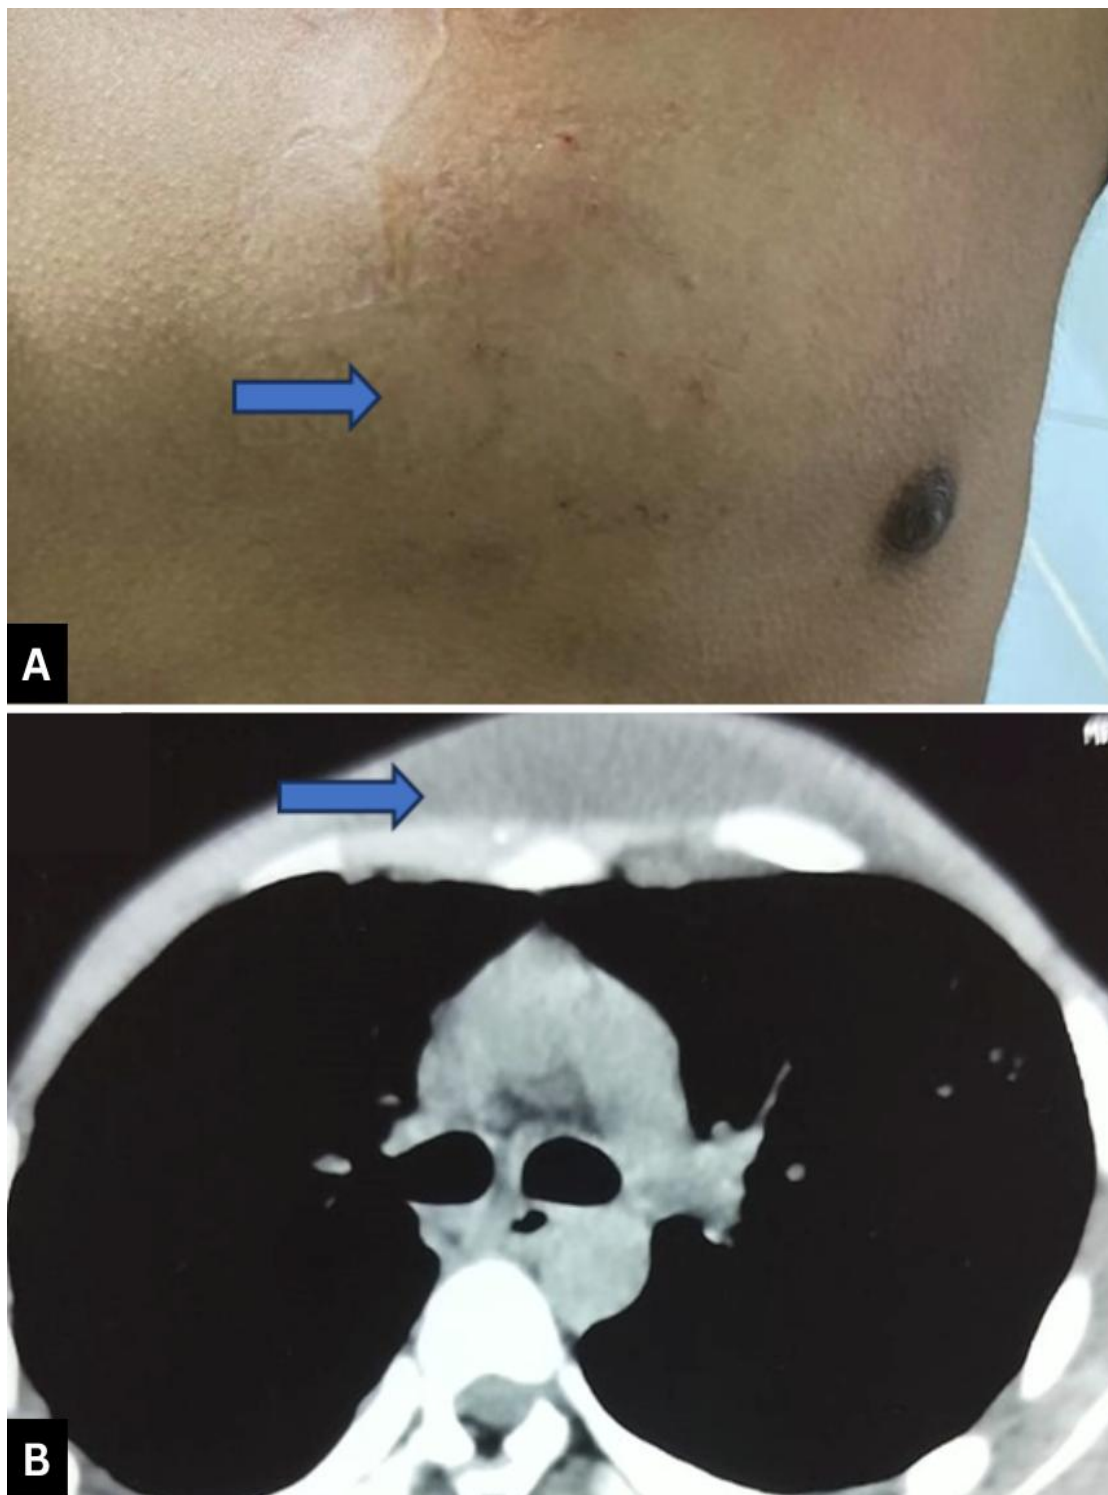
A) chest wall swelling. B) CT chest showing subcutaneous collection
